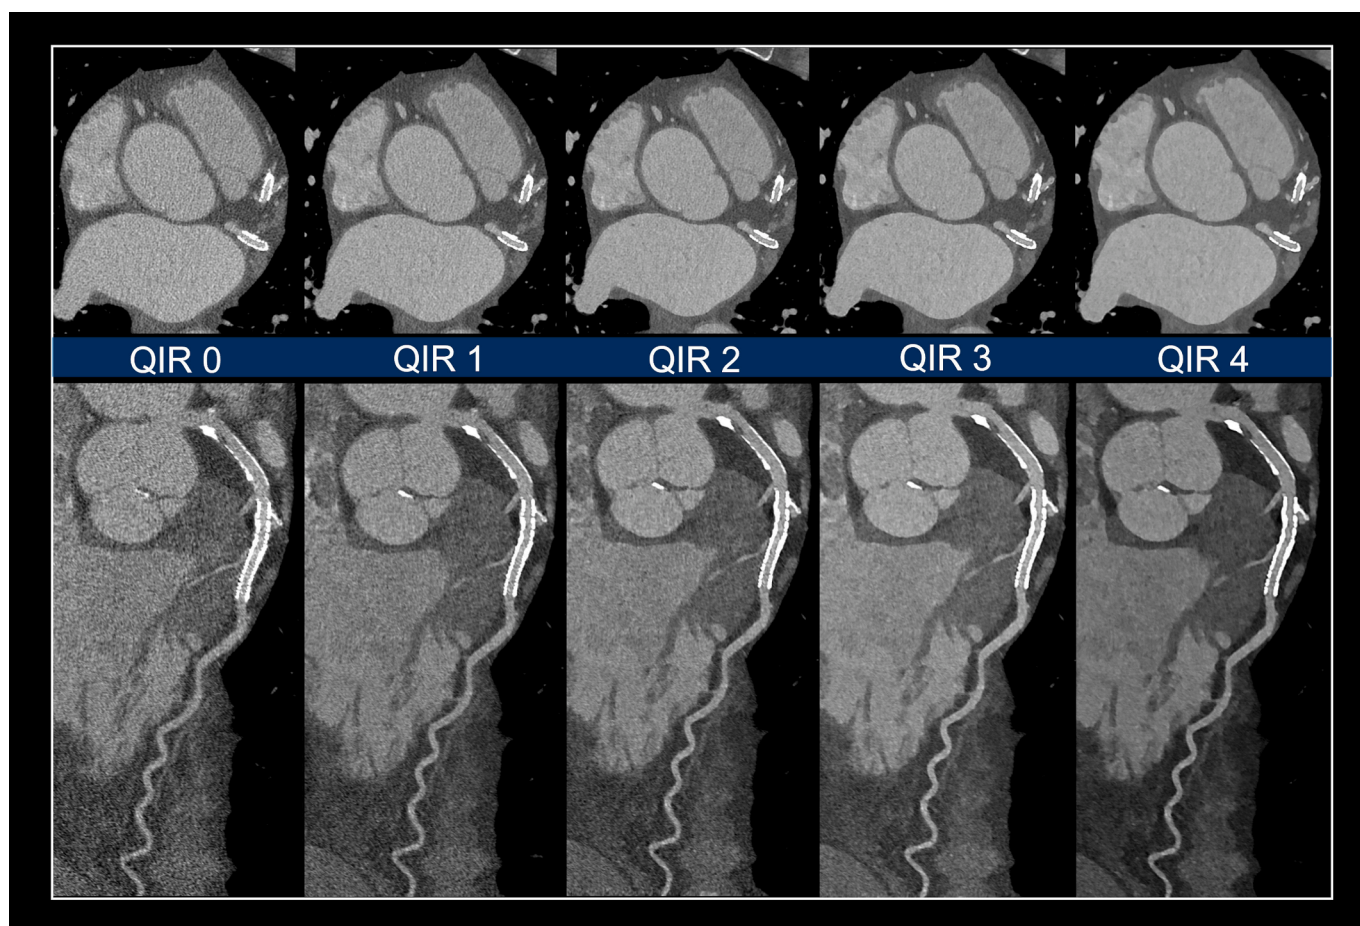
Representative CTA images of coronary stents using UHR acquisition mode reconstructed using 0.2 mm slice thickness and sharp convolution kernel dedicated for vascular imaging (Bv56) with different strength levels of iterative reconstruction (QIR 0–4).
